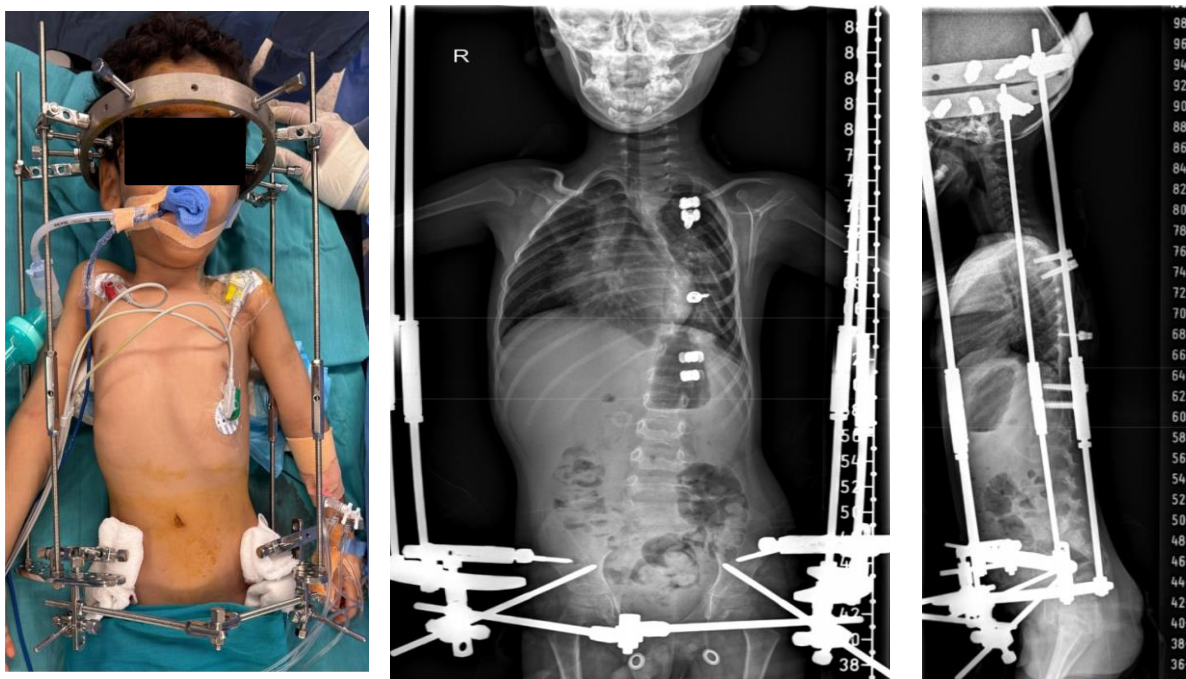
Intra operative Halo-pelvic traction application and interval AP/lateral radiographs during the traction phase, demonstrating gradual spinal elongation and coronal/sagittal correction.
